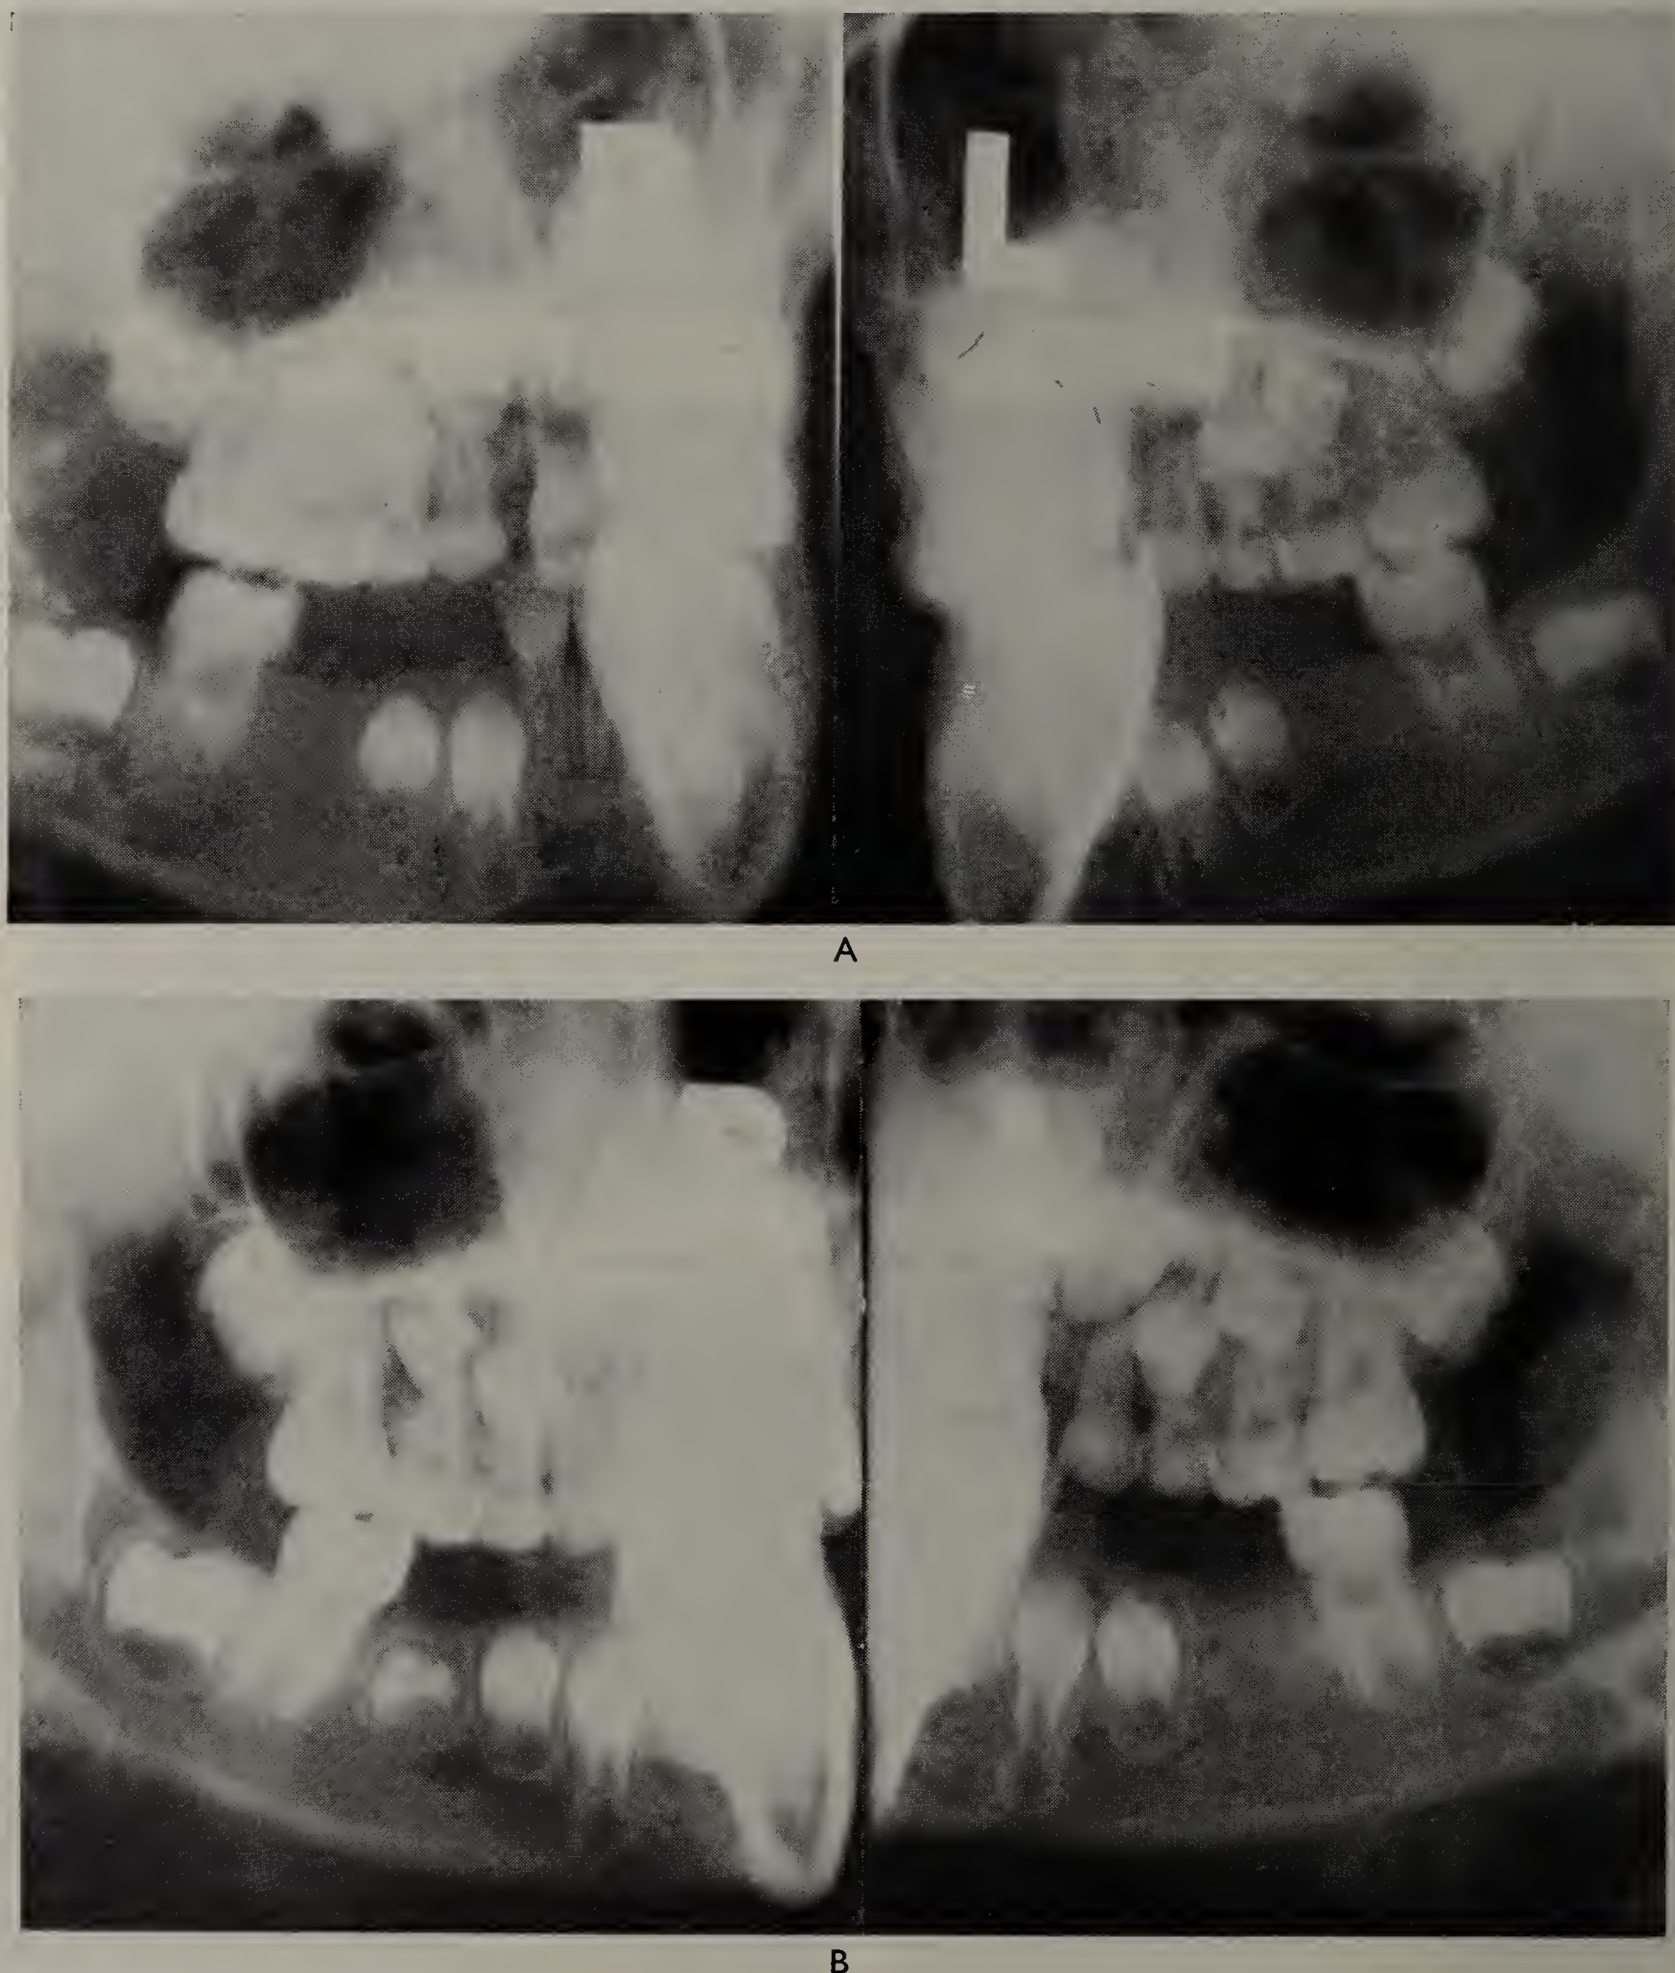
Oblique lateral jaw radiographs of A, Janet and B, Carol showing absence of  $\bar{5}$  in Janet only and retarded development of  $\bar{5}$  in Carol.
